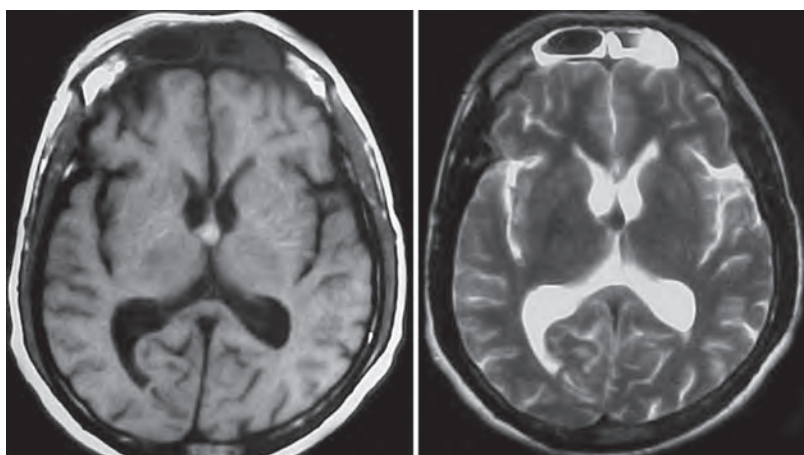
MRI of the brain (T1, T2) showing anterior third ventricular colloid cyst
